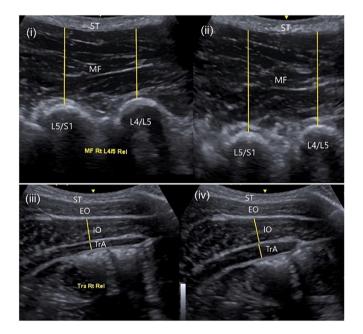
Parasagittal ultrasound image of the multifidus muscle thickness measured in relaxed (i) and contracted (ii) conditions. Transverse ultrasound image of the internal oblique and transversus abdominis muscle thickness measured in relaxed (iii) and contracted (iv) conditions.
